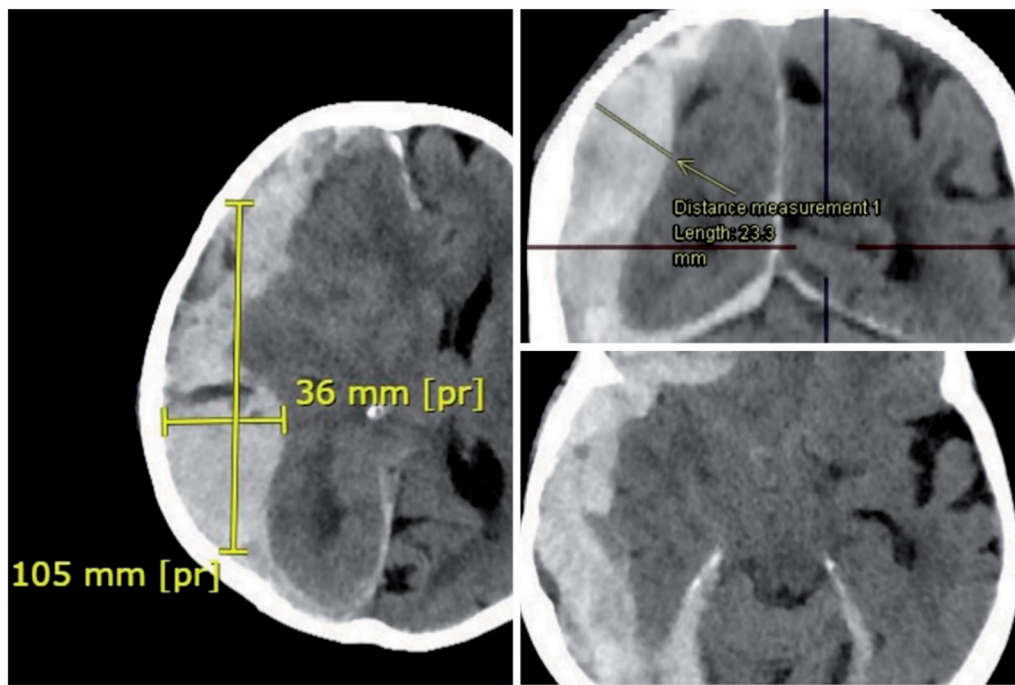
The Helsinki CT score calculations; Mass lesion as SDH = 2 points, Mass lesion size > 25 cc = 2 points, absence of IVH = 0, Basal cisterns are compressed = 1 point, Sum = 5.
